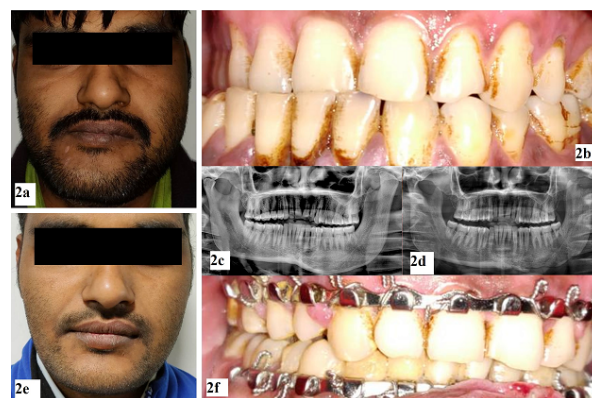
f): a) Pre-operative patient picture depicting vertical enlargement of the left mandible along with bowing of the left lower border of the mandible; b) Deviation of chin to right side along with dental midline shift to the right side; c) Orthopantomogram (OPG) revealed bulbous left condyle with medial outgrowth; d) Post-operative OPG depicting left TMJ condylectomy, along with shaving of the left lower mandibular border; e-f) swing back of the mandible was observed improving the facial symmetry and attaining positive overjet
